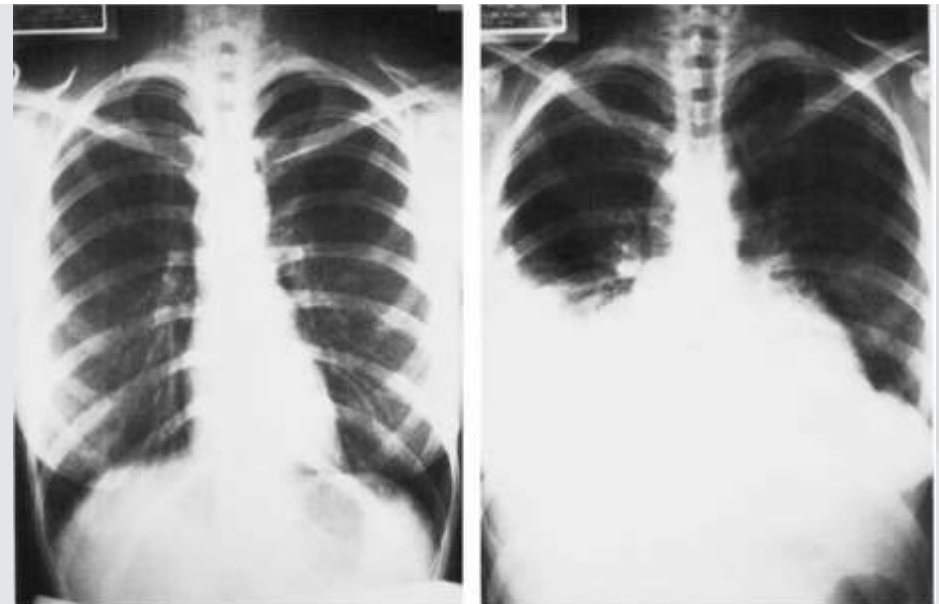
(*left*). Normal chest x-ray film during adriamycin therapy (case 1).
